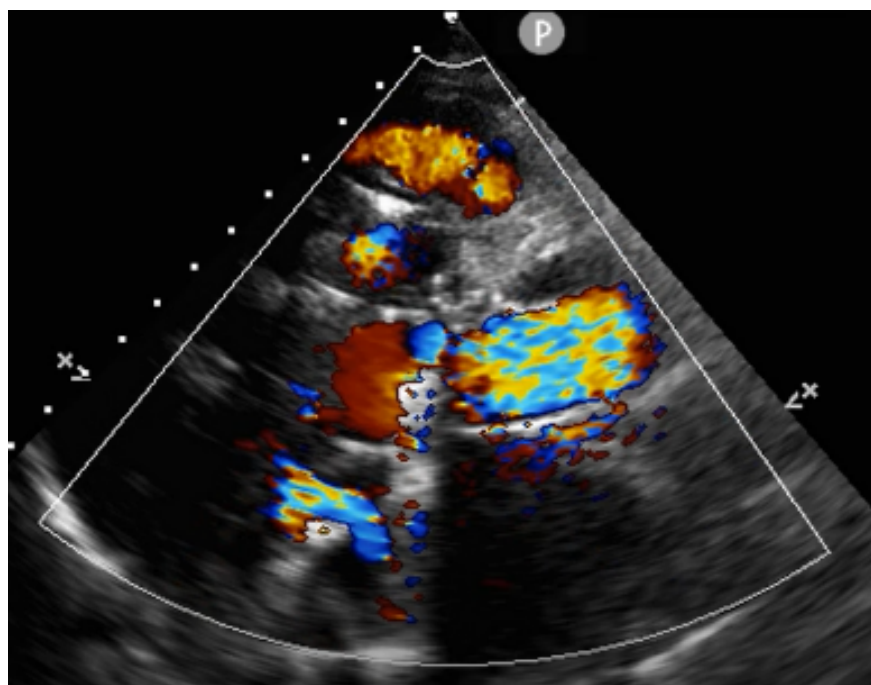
parasternal long axis and short axis view revealed the prosthetic aortic valve worked normally, and the mentioned cystic cavity was separated by thrombus and color doppler did not detect communication with aortic artificial blood vessel.
